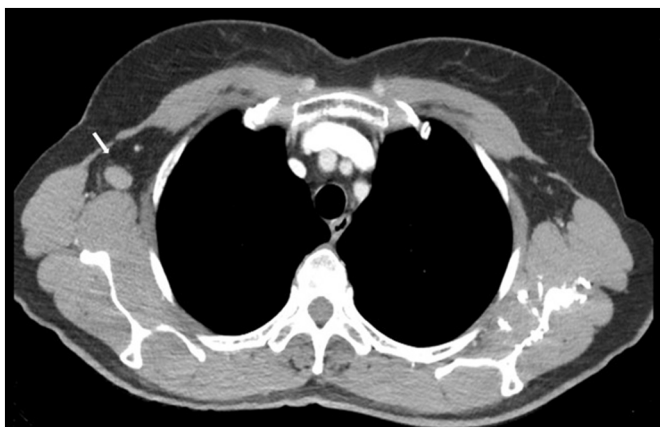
CT scan demonstrating right axillary lymph node enlargement (white arrow) in case one prior to NACT treatment.
